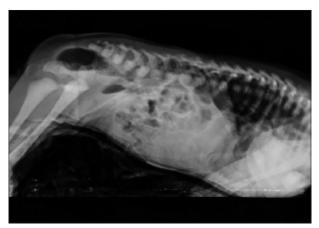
Prone cross table lateral X-ray showing gas shadow between PC line and I line indicating intermediate anorectal malformation.
